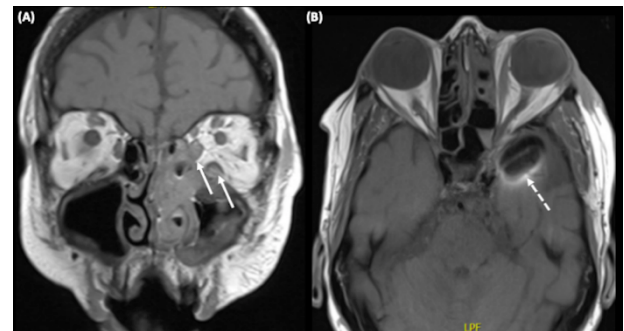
Pre-operative MRI brain/orbits (A) T1 coronal view showing opacification of the left maxillary and ethmoid sinuses as well as thickening of the inferior and medial rectus muscles (white arrows). (B) MRI brain/orbits T1 axial view showing inflammatory changes involving the intraconal optic nerve and thickening of the left medial rectus muscles. Image quality at the cavernous sinus and orbital apex is degraded by artefact related to middle cerebral artery metallic clip (dashed arrow).
